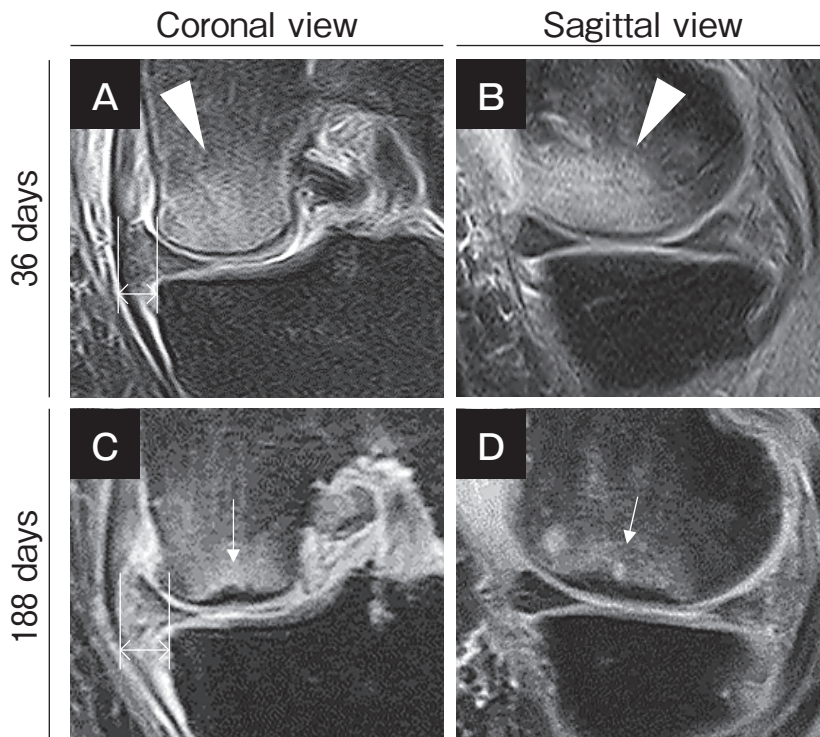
MRI of patients who underwent total knee arthroplasty. (A, B) Images 36 days after MMPRT showing SIFK grade 1 (arrowhead) and severe MME (5.5 mm). (C, D) Images 188 days after MMPRT showing SIFK grade 3 (arrow) and MME progression (7.1 mm).
